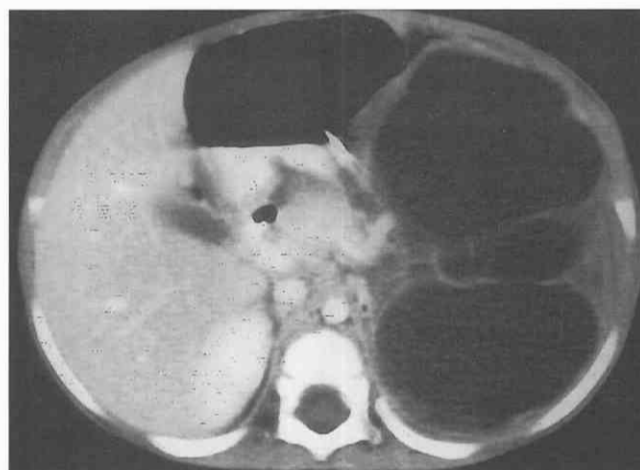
Pancreatic pseudocyst with internal septations. CT scan through the upper abdomen in a patient with acute pancreatitis shows a large multiseptated pseudocyst in the left upper abdomen.
